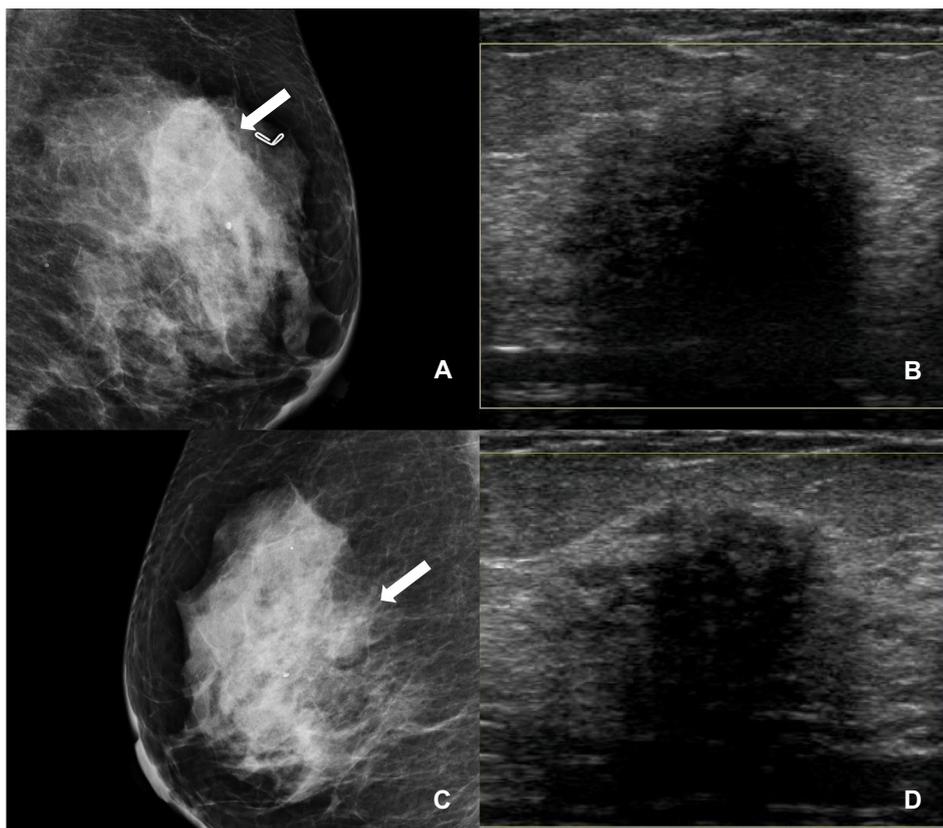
Mammography and ultrasound images from a 44-year-old woman with type 1 DM, presenting with a palpable lump in her right breast.
